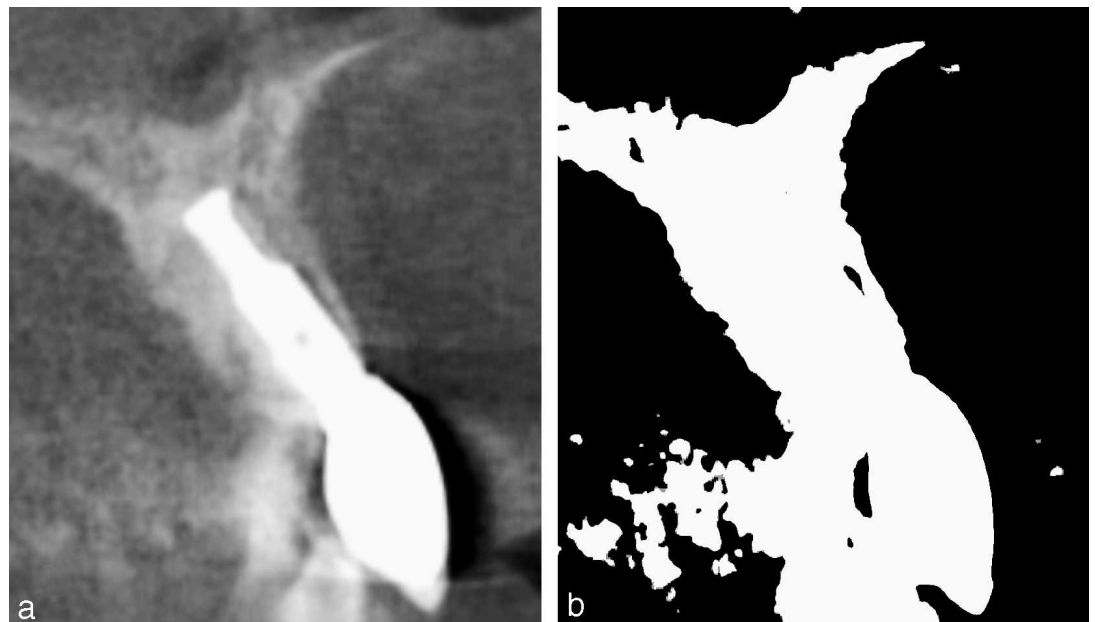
Cross-sectional cone-beam computed tomography (CBCT) images with conventional contrast (gray-scale) and binary threshold values. (a) Conventional contrast (gray-scale) image. (b) Black and white binary image.
